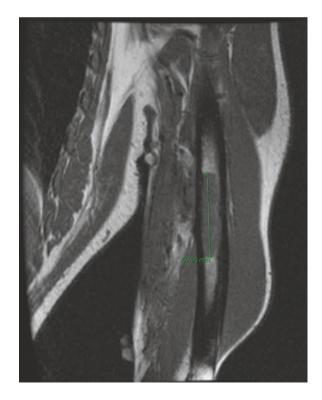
T2 fat-saturated MRI image of a  $9 \times 4.5 \times 4.5$  cm bicipital Ewing sarcoma in a 34-yearold woman without other symptoms. *Red arrow*: possible local bony involvement with tumor. The patient had no evidence of viable tumor in the bone after neoadjuvant chemotherapy
